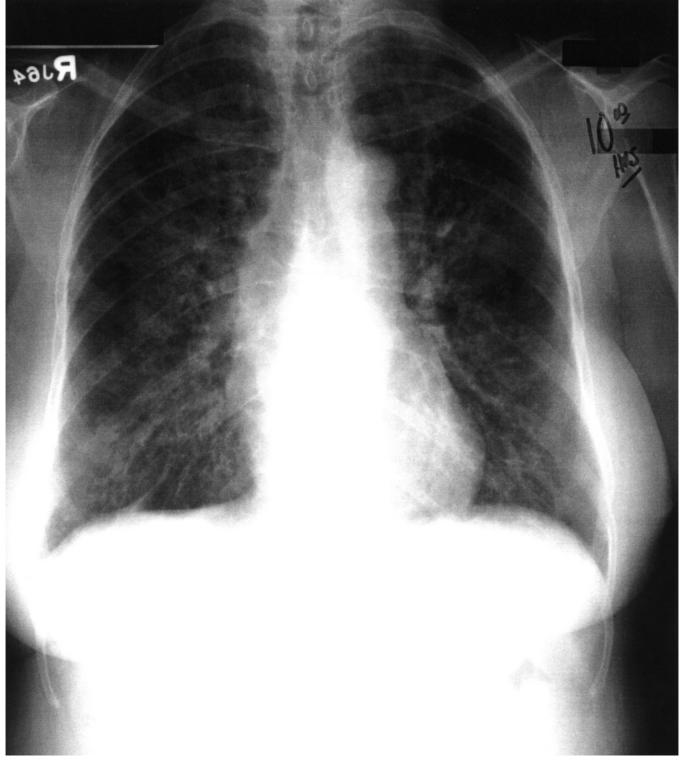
The same patient ve days later. Despite intravenous cotrimoxazole and oral prednisone, she became progressively hypoxemic and her chest radiograph reveals worsening in Itrates. She subsequently improved without a change in therapy, and did not require mechanical ventilation.
